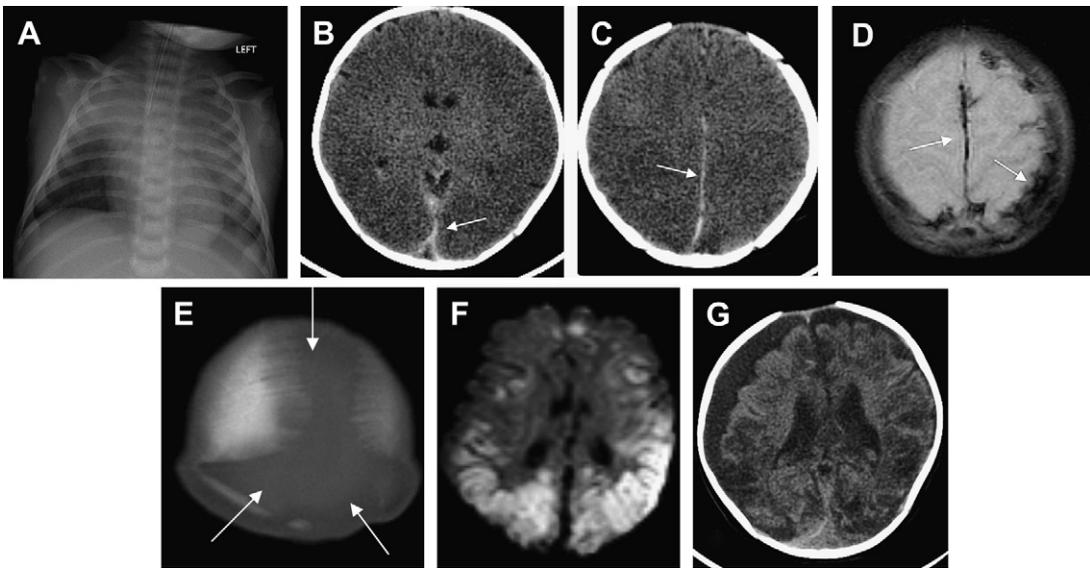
Five-week-old infant with triad and alleged NAI; also, cold symptoms, vitamin D undersupplemented, acute choking episode during feeding, and status epilepticus. Chest film (A) shows bilateral lung opacities. CT (B, C) plus T2* MR imaging (D) shows bilateral cerebral edema with bilateral thin, acute-subacute hemorrhages (or thromboses) about the falx, tentorium, and convexities (arrows). Vertex CT (E) shows suture diastasis versus pseudodiastasis (arrows) (craniotabes?). DWI (F) shows global hypoxic-ischemic injury. Later CT (G) shows atrophy and chronic SDH.
